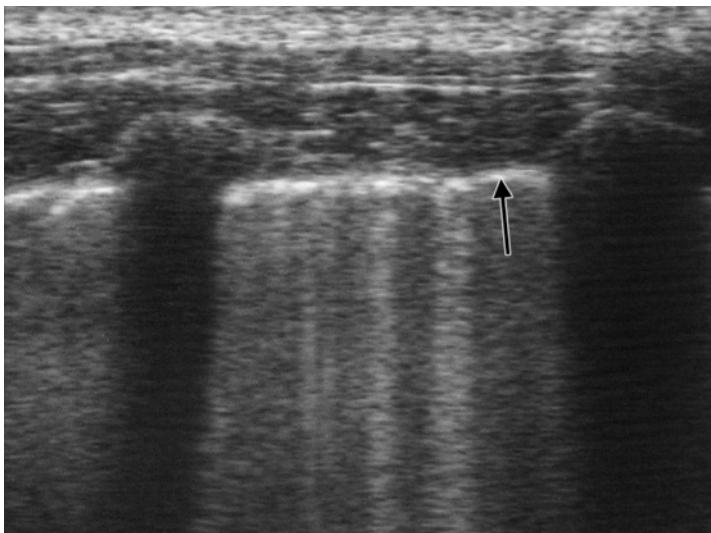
Ultrasound image of the pleura. In the sagittal plane tangential to the ribs there is a streaky hyperechoic line along the impedance mismatch between the chest wall and the air-filled lung (black arrow).
